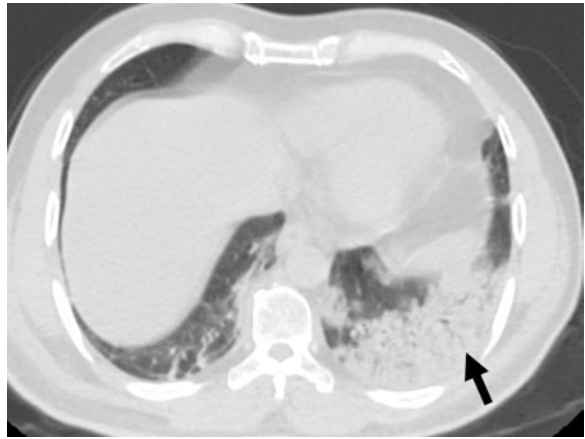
Axial chest CT. A large area of consolidation in the left lung base in a patient with COVID-19 pneumonia. Classical air bronchograms within the lesion (black arrow)
